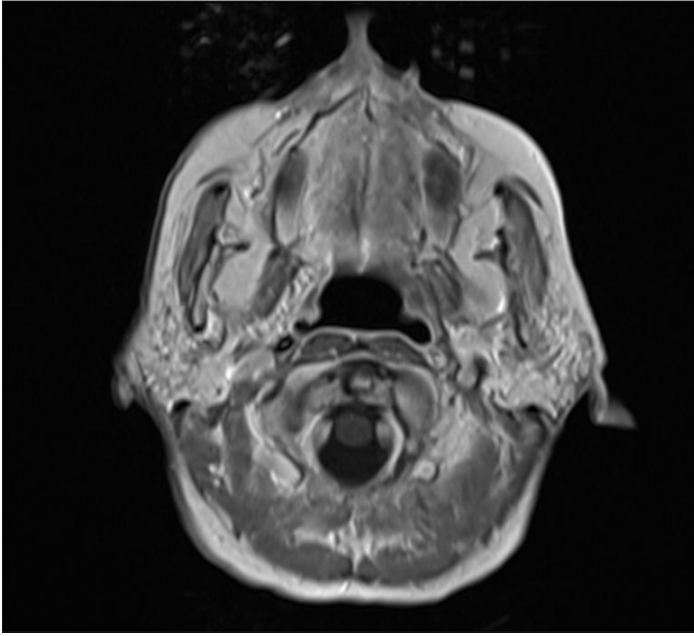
Axial view of the nasopharynx on T1-weighted MRI (after treatment)
